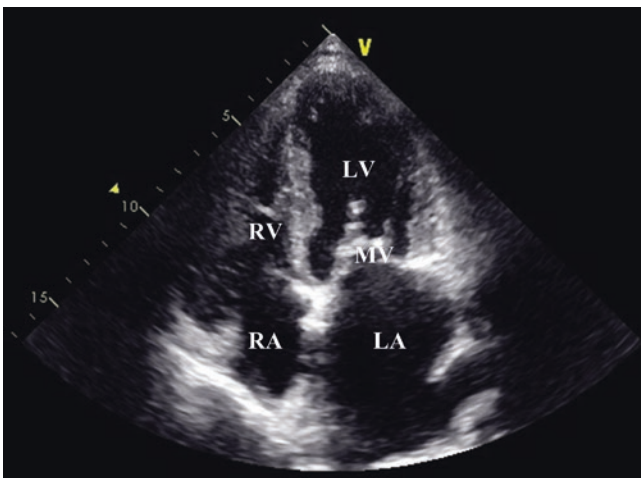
Mitral stenosis, apical four-chamber view. In this view, the left atrium (LA), right atrium (RA), left ventricle (LV), and right ventricle (RV) are seen. The left atrium is markedly enlarged. The mitral valve (MV) appears echo dense and thickened, the posterior leaflet is immobile and anterior leaflet has restricted mobility. This is consistent with rheumatic mitral valve stenosis. See also Video 20.2
